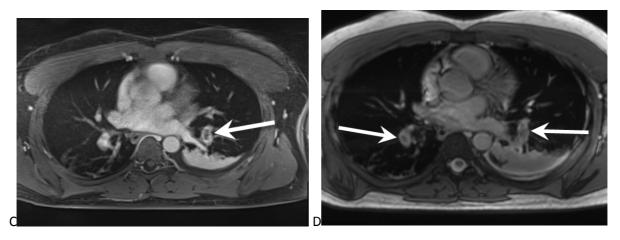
37 year old male presenting to the emergency department with shortness of breath. Due to the patient's young age, an MRI was performed and demonstrated bilateral pulmonary emboli (arrows, (a) axial reformatted high flip angle magnetic resonance angiography, low flip angle T1W 3D GRE with (b) breath hold and (c) free breathing radial techniques and (d) free breathing steady state free precession sequence).
